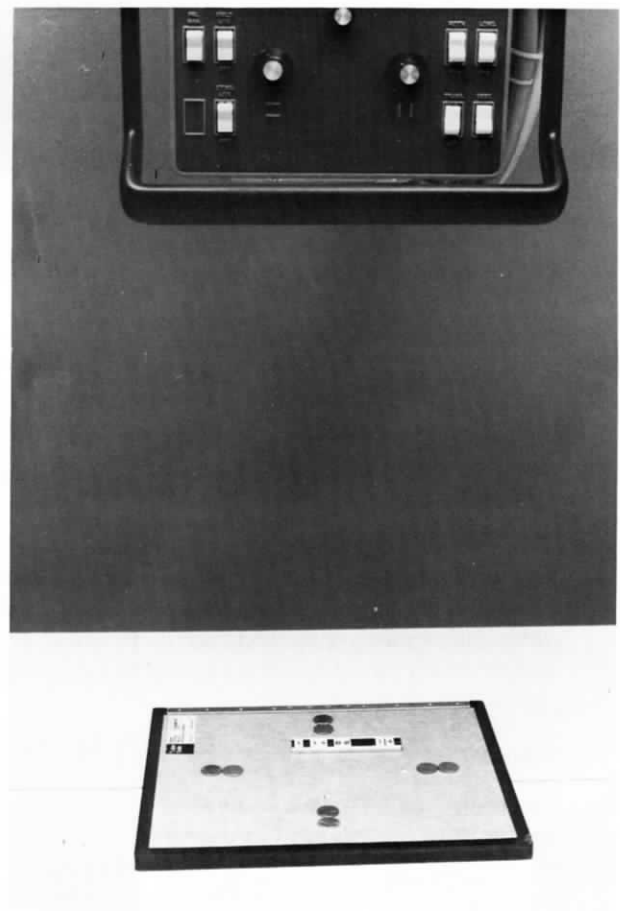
The eight-penny x-ray field-light field congruence test uses lead letters to indicate the orientation of the film.
